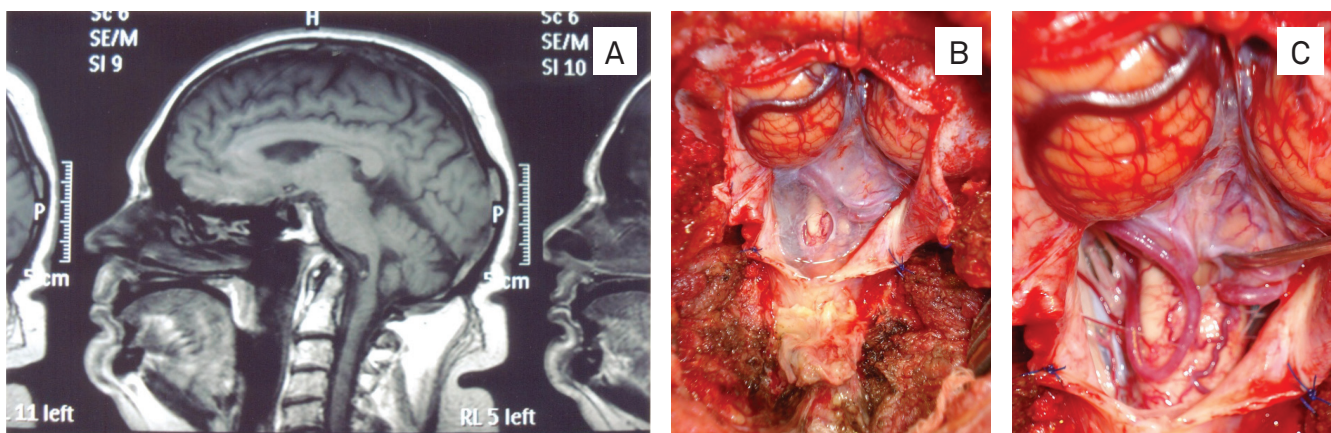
(A) Postoperative MRI showing basilar impression with compression of the brainstem. (B) Arachnoid adhesions of the posterior fossa. (C) A large opening of the fourth ventricle and looping sign of both posterior inferior cerebellar arteries.
